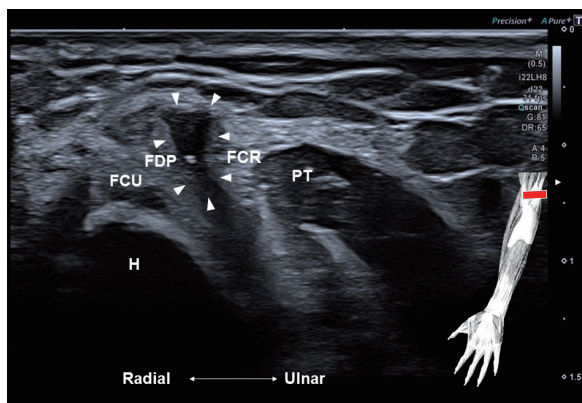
Short-Axis Ultrasound Image of the Common Flexor Tendon Demonstrating a Tear Involving the Flexor Digitorum Superficialis Tendon (White Arrowheads)
